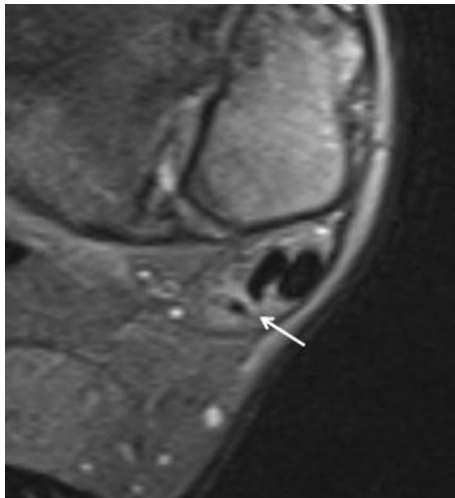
Axial PD FS MR image: the examination reveals an accessory peroneus quartus tendon (*arrow*), the insertion of which varies
